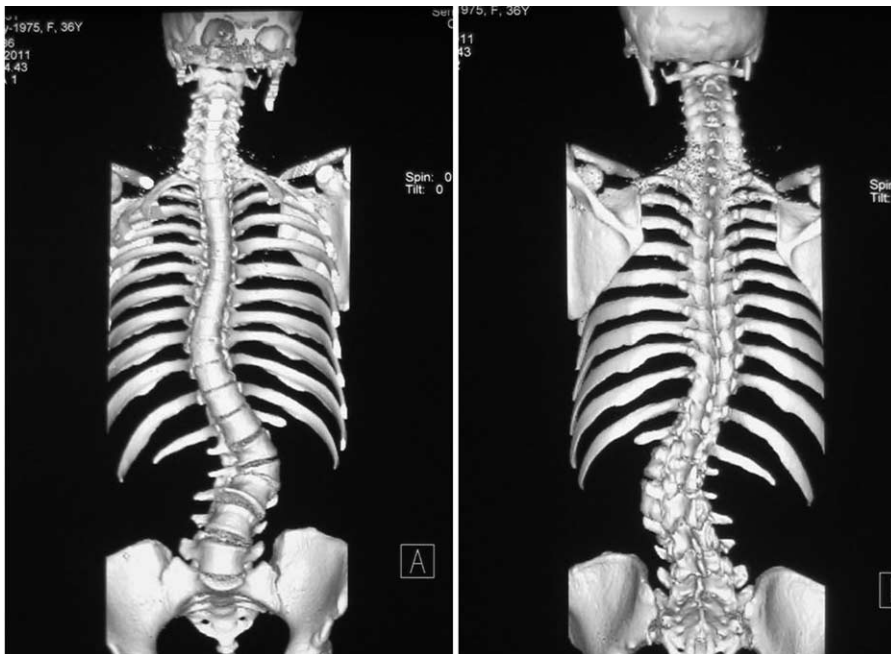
Computed tomography revealed a wedge-shaped vertebra of lumbar 2 and 3.
